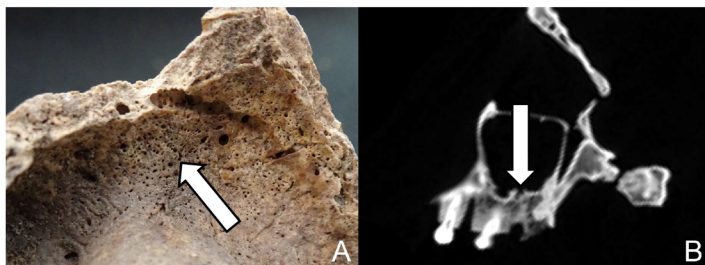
Bone resorption associated with CMS. A) Macroscopical view; B) CT view
